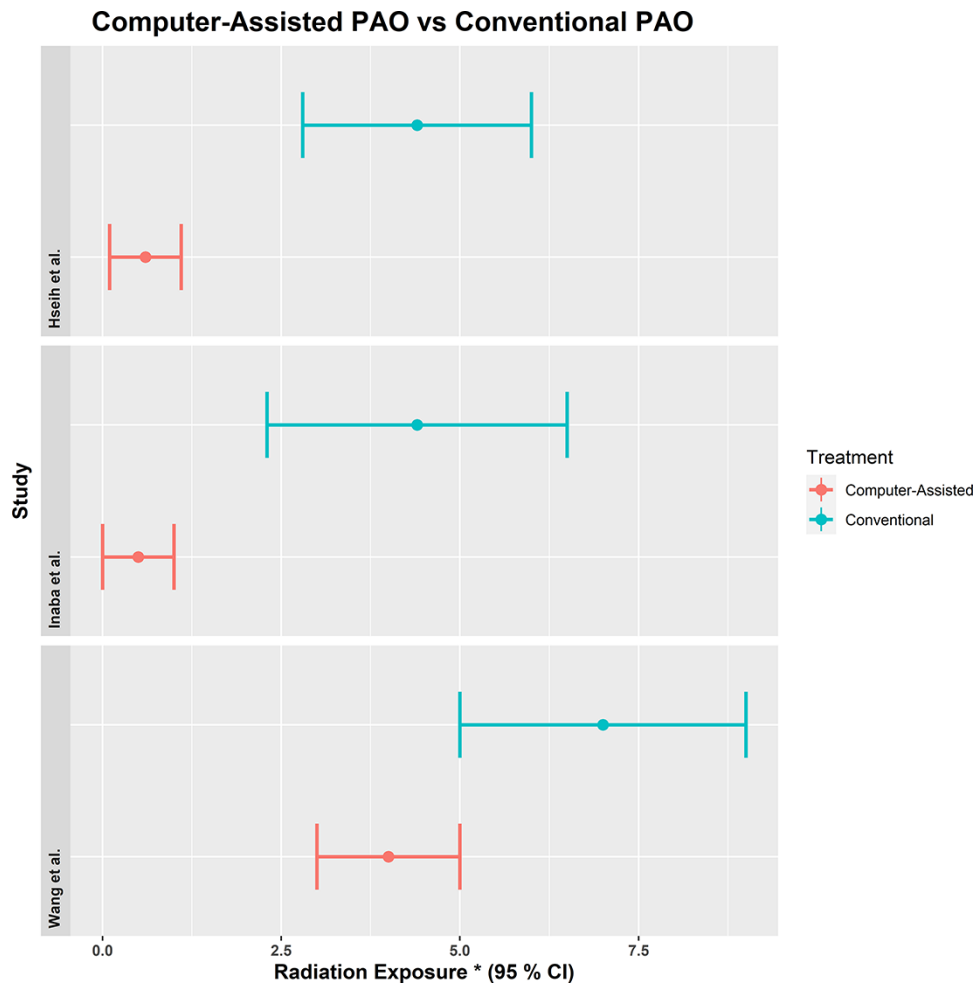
Graphical depiction of the standardized means for radiation exposure, comparing computer-assisted versus conventional PAO. *Hsieh *et al.* [19] and Wang *et al.* [23] results are reported as number of intraoperative radiographs, and Inaba *et al.* [16] results are reported as 10-s units of fluoroscopy time.
